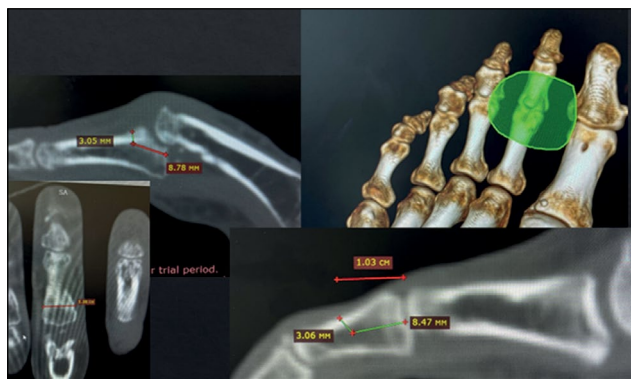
Marking of computed tomography.
